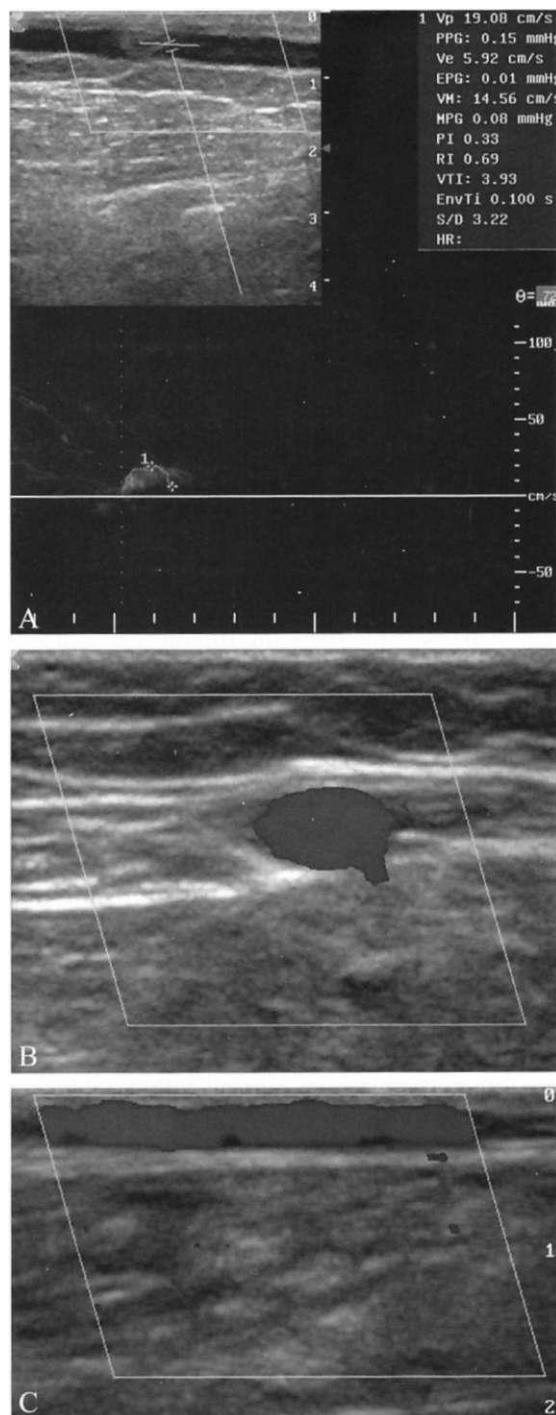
Dopplerography (A) and scans in the transverse (B) and longitudinal (C) projections of the right GSV in the lower third of the thigh after 3-month treatment with MPPF. The diameter of GSV in the problem area is 5.5 mm on the right side, and no reflux throughout the length of GSV is observed.
